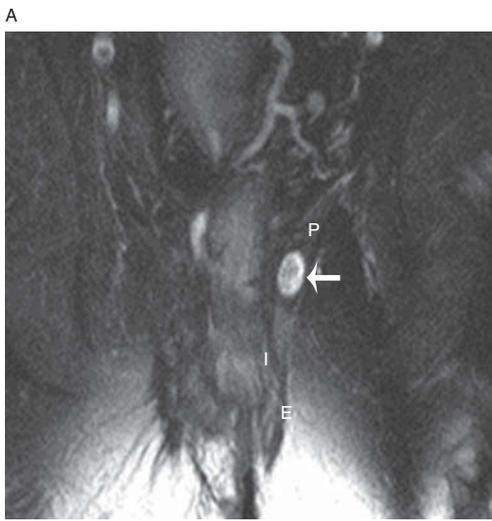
Active suprasphincteric fistula in a 40-year-old male. Coronal T2-weighted image with fat saturation (A) reveals fistula (arrow) extension above the level of the anal sphincter muscles (I: internal and E: external anal sphincters) into the left puborectalis muscle (P). Axial contrast-enhanced T1-weighted image with fat saturation (B) also demonstrates extension of the fistula (arrows) into the left ischioanal fossa.
